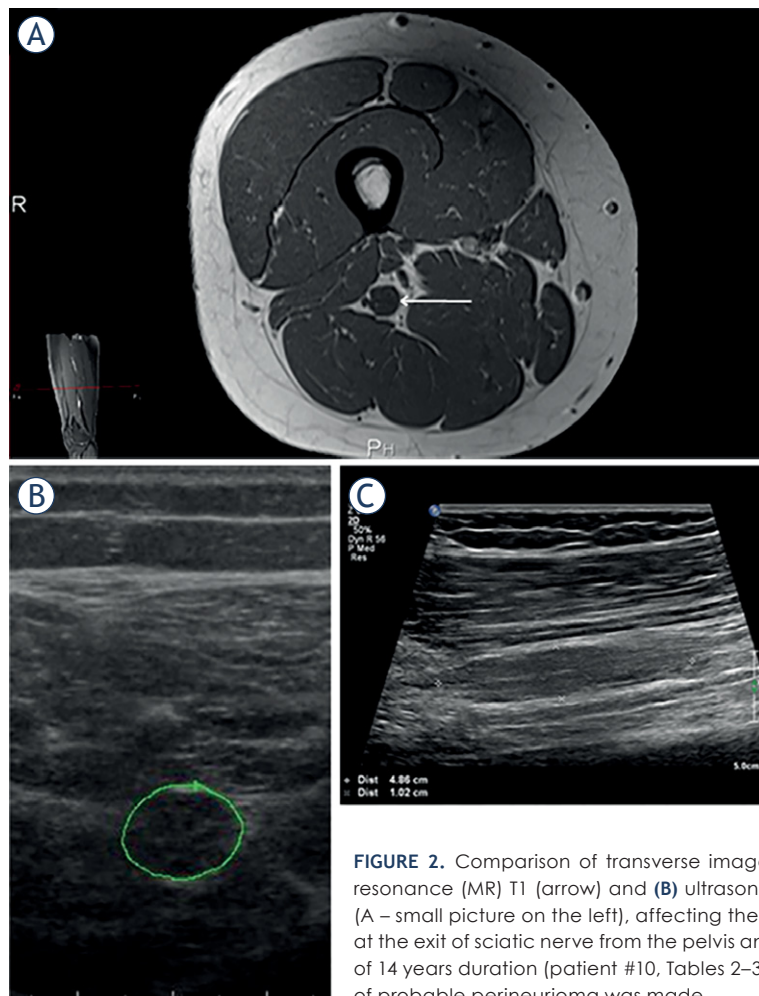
Comparison of transverse image of the sciatic peripheral nerve tumour (PNT) on (A) magnetic resonance (MR) T1 (arrow) and (B) ultrasonography (US). (C) Longitudinal US view of PNT in the middle thigh (A – small picture on the left), affecting the tibial portion of sciatic nerve. In this 22-year-old girl MR revealed at the exit of sciatic nerve from the pelvis another PNT affecting its fibular portion, and causing right foot drop of 14 years duration (patient #10, Tables 2–3). Based on clinical and imaging features in this patient diagnosis of probable perineurioma was made.
